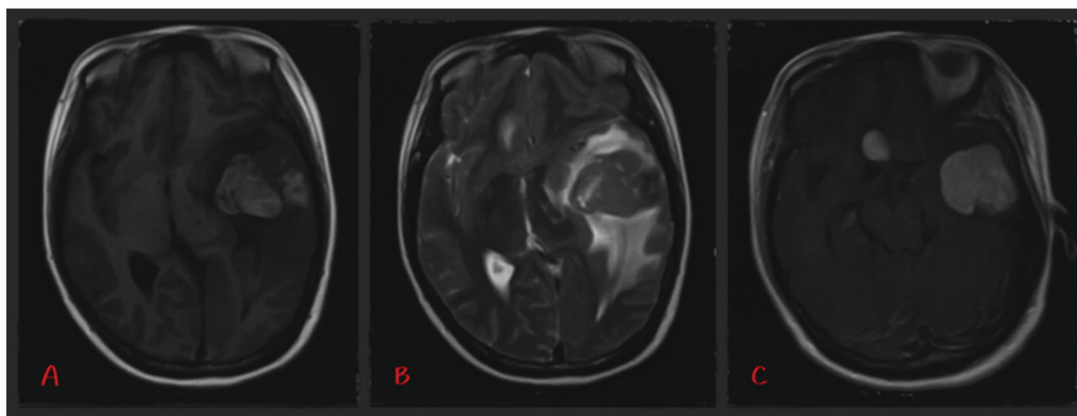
Preoperative brain MRI images. (A, B) Axial view, lesions on T1WI and For Peer Review Only T2WI. (C) Axial view, contrast-enhanced T1W.
